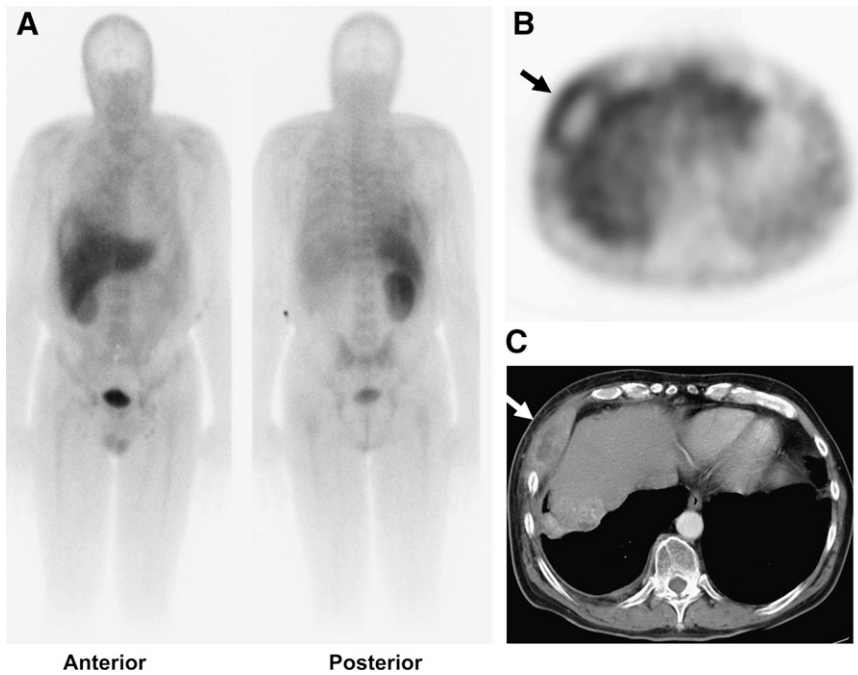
Anterior and posterior whole-body planar (A) and transverse SPECT (B) ^{99m}Tc -EC20 images in 59-year-old man with renal cell carcinoma revealed large, destructive right chest wall metastasis (arrow). Scintigraphic findings correlated well with those on CT image (C), including photopenia in area of central necrosis. These scintigraphic results suggested that lesion was FR+. Note faint uptake in left renal fossa, thought to represent postsurgical inflammation. Mild uptake in right lung and right paratracheal region corresponded to other sites of metastatic disease demonstrated on CT (not shown). Small foci of mild ^{99m}Tc -EC20 uptake were noted in inguinal regions bilaterally; this finding was seen in many patients and may be secondary to FRs on activated macrophages.
